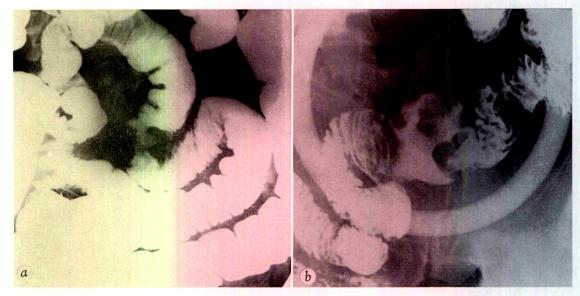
(a) Annular, ulcerating adenocarcinoma of ileum producing mucosal type of filling defect on spot roentgenogram. Lumen is encroached upon by tumor. In this case, ileum was filled at time of barium enema. (b) Hodgkin's variety of malignant lymphoma producing mucosal type of filling defect on spot roentgenogram. In this case, lumen is widened because of extensive ulceration of tumor.
